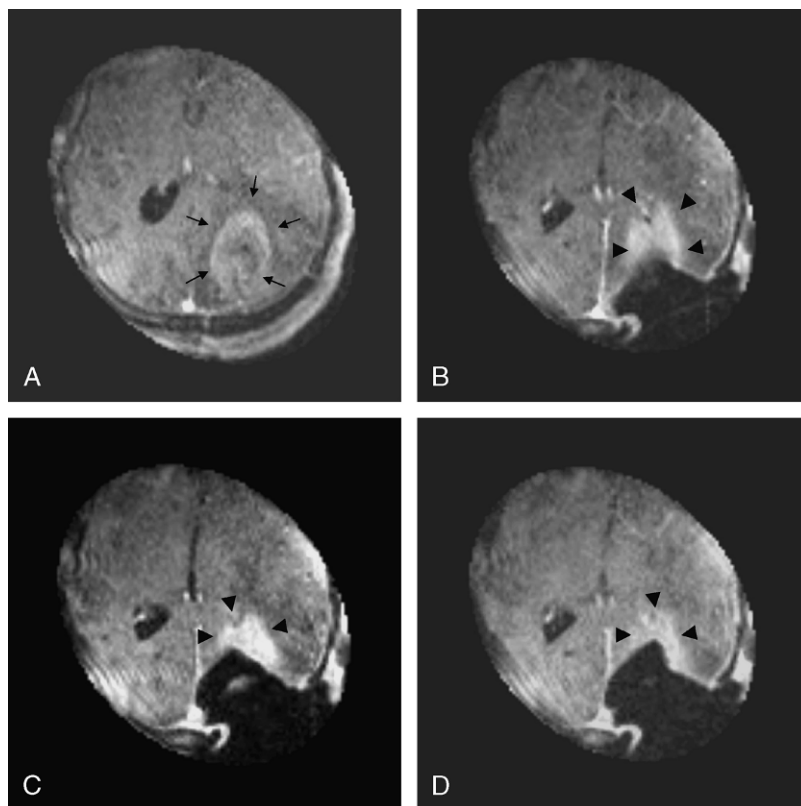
A left occipital glioblastoma multiforme is shown on perioperative MR (A, arrows), and the progress of excision is demonstrated in sequential intraoperative MR images (B, C, and D), showing progressive reduction of tumor volume and associated changes induced by the surgery (arrow heads).
